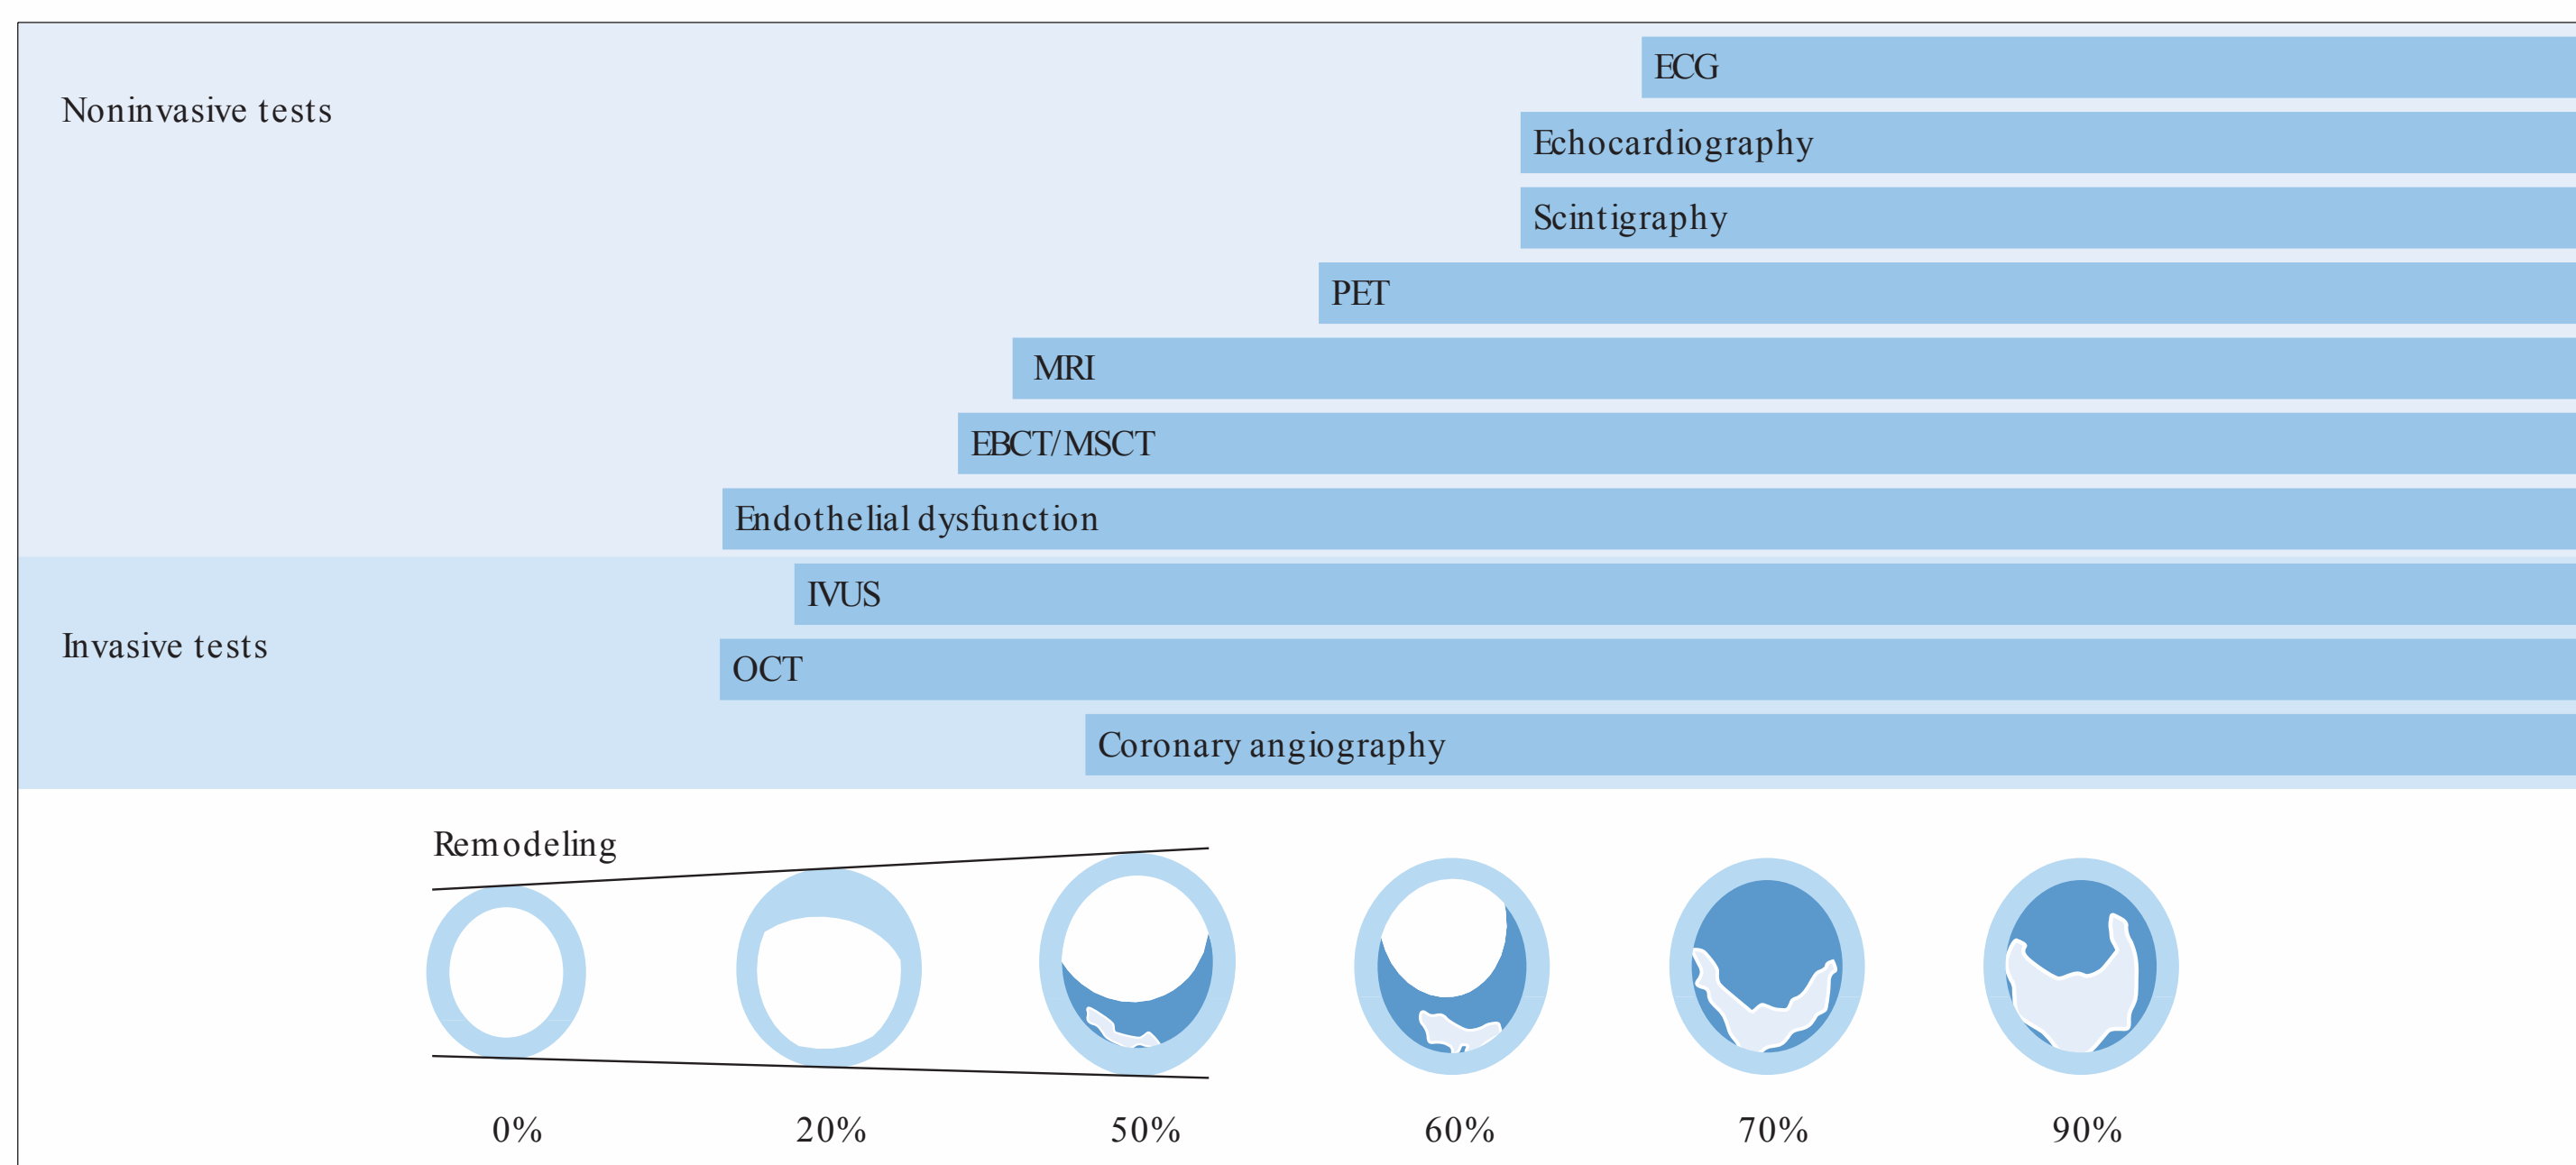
Review of invasive and noninvasive tests for coronary sclerosis and myocardial ischemia, shown in relation to coronary plaque formation and positive remodeling as described by Glagov et al. (1997).⁶ The detection of endothelial dysfunction is the first invasive and noninvasive sign of incipient coronary disease. Initial signs can be detected invasively by optical coherence tomography (OCT). Intravascular ultrasound (IVUS) is the most widely used clinical modality for the early detection of coronary sclerosis. Even Sary stage II and III lesions can be visualized. Calcifications can be detected with high sensitivity along with thrombus formation and lipid deposits. Electron-beam CT (EBCT) and multislice CT (MSCT) are the current modalities of choice for detecting coronary calcifications noninvasively. Calcifications are initially intracellular and then extracellular and occur as early as Sary stage III. MRI can
